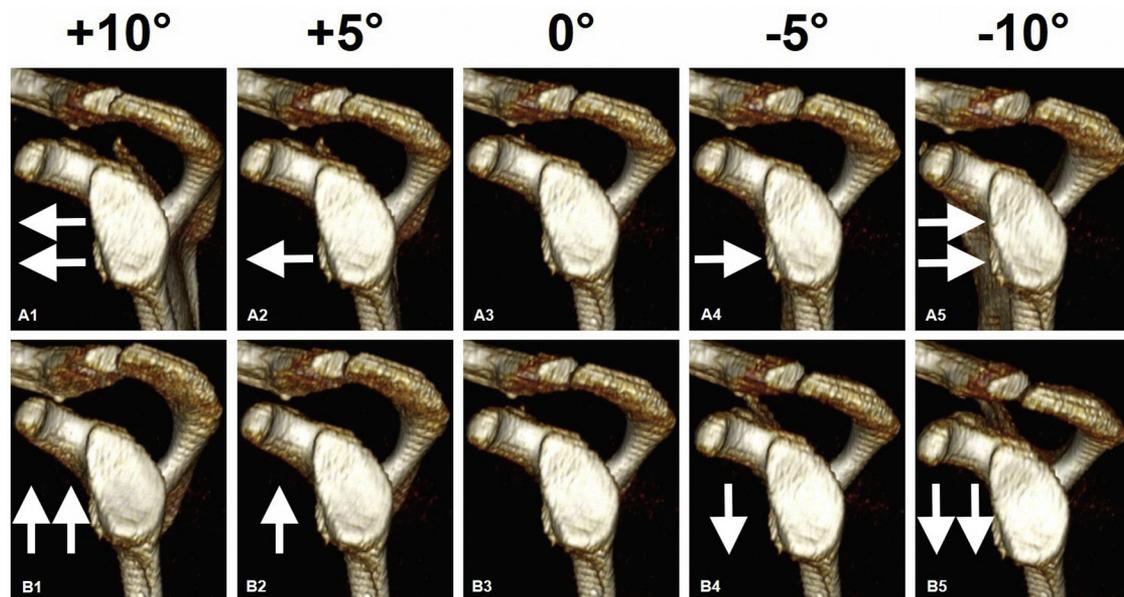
Three-dimensional computed tomographic en-face view images of the same left glenoid with horizontal (A) and vertical (B) variation of the orientation of the scapula (each white arrow indicates a tilt in the according direction by 5°).
